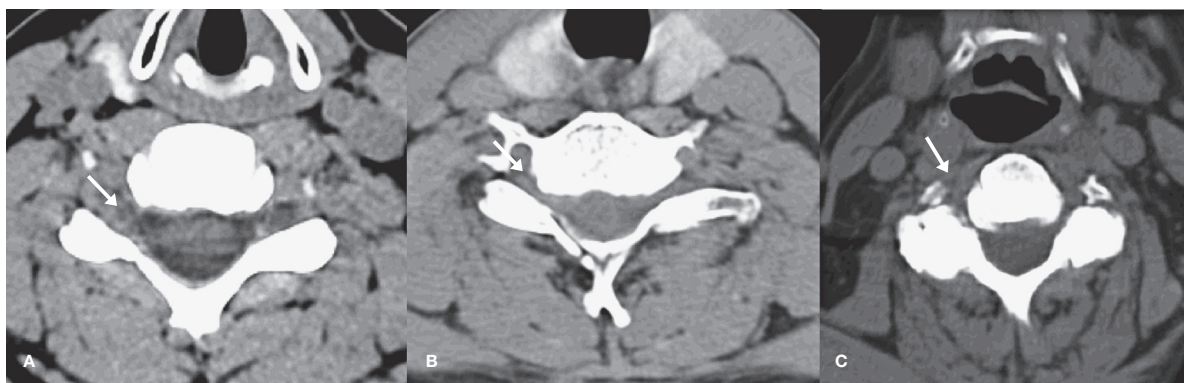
Axial non-enhanced CT images in three patients demonstrating examples of neural foramina grading. A) Normal to mild degenerative narrowing. B) Moderate degenerative narrowing. C) Severe degenerative narrowing.
